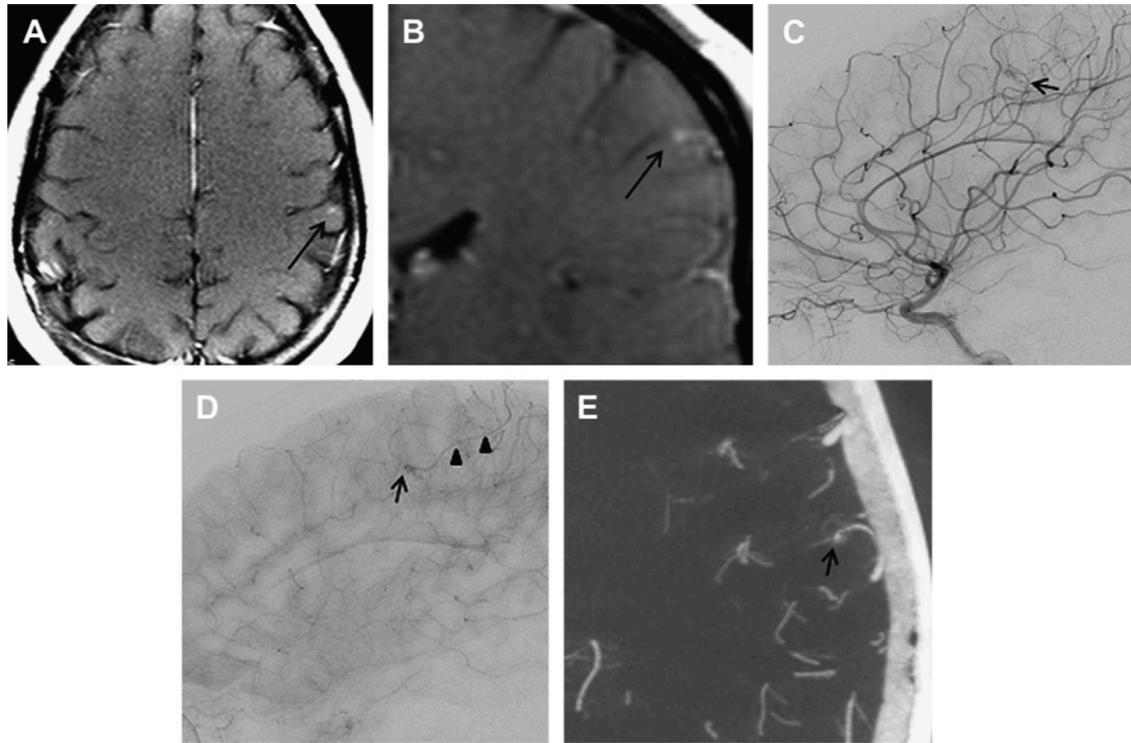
A 28-year-old man with recent diagnosis of hereditary hemorrhagic telangiectasia (HHT). Axial (A) and magnified coronal (B) T1 postcontrast images of the brain show an enhancing cortical lesion (long arrow) involving the left precentral gyrus. Although nonspecific, a lesion like this should raise a suspicion for a micro-AVM in patients with HHT. Micro-AVM nidus (short arrow) was confirmed on sagittal digital subtraction angiography (DSA) image in early arterial phase (C). Sagittal DSA image in capillary phase (D) shows micro-AVM nidus (short arrow) with single early draining vein (arrowheads). The nidus (short arrow) is presented on axial, magnified C-arm cone-beam CT image (E).
